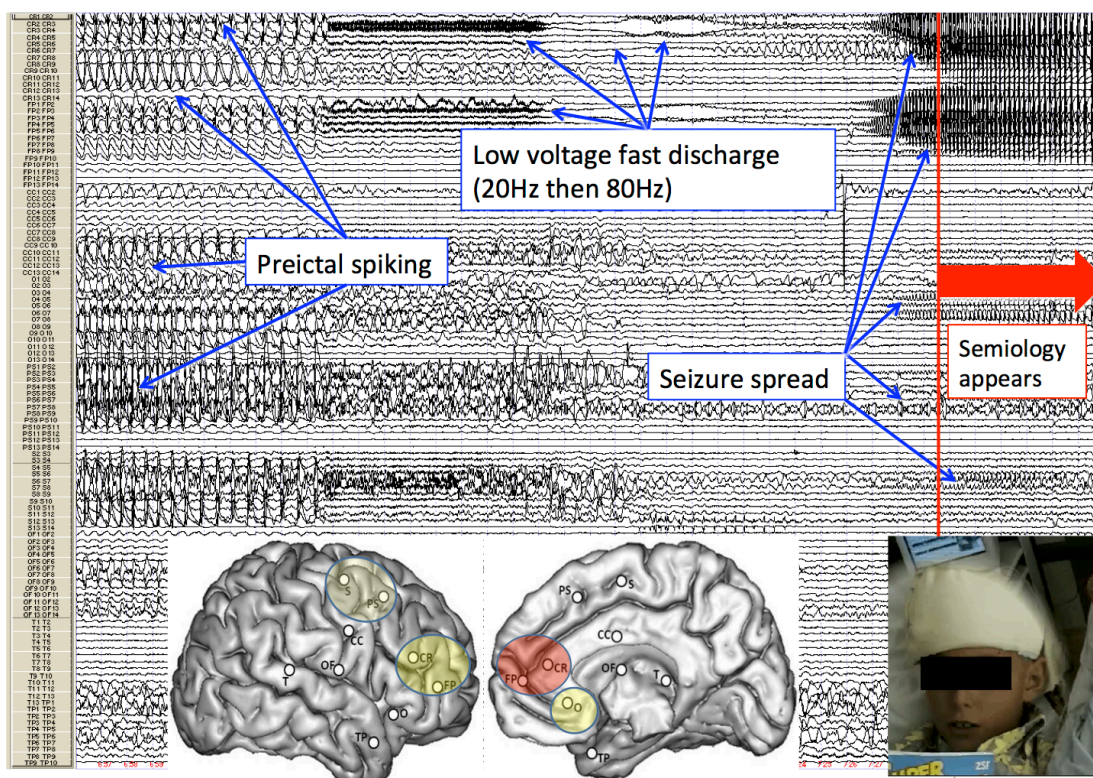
Example of a prefrontal seizure recorded with SEEG, in a patient with MRI-negative cortical dysplasia. Preictal rhythmic spiking precedes the onset of a low voltage fast discharge (gamma band), recorded from a relatively focal region of right anterior prefrontal cortex including the frontal pole (maximal in electrodes CR and FP). The appearance of clinical signs occurs several seconds after the fast discharge, at which time slower rhythmic discharges (theta band) are also seen in anterior premotor regions and anterior cingulate gyrus. Identical seizures could also be triggered in this patient by stimulating electrodes CR and FP.
